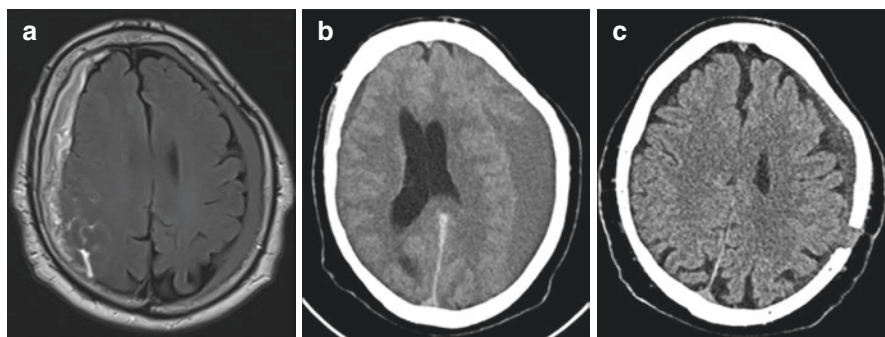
(a) Preoperative brain MRI demonstrating bilateral paucisymptomatic frontoparietal CSDH treated conservatively. (b) One-month follow-up CT scan demonstrating obvious volume increase of the left CSDH and significant reduction of the right CSDH. (c) Postoperative CT scan showing residual left subdural collection
